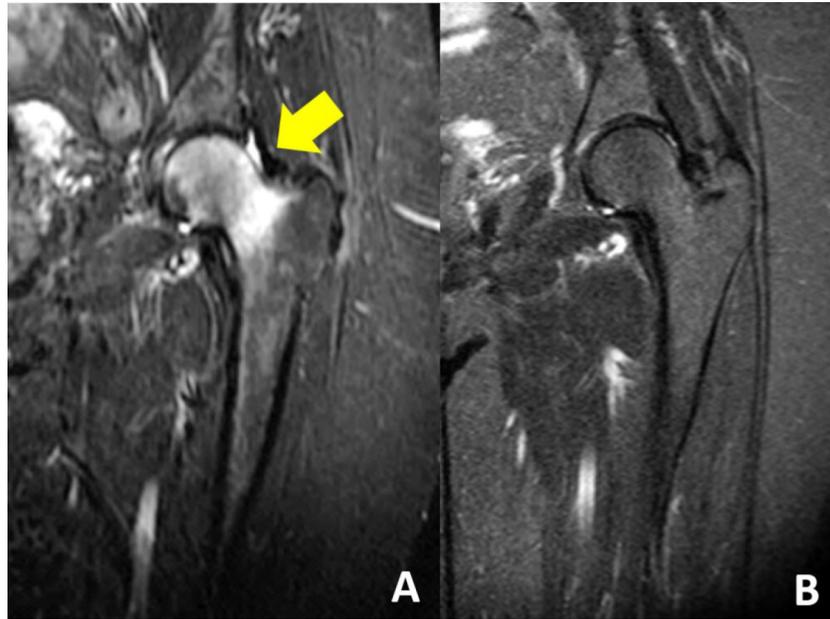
Magnetic resonance imaging (MRI) of the left hip of the patient before (A) and 3.5 months after (B) a zoledronic acid (ZA) infusion (Coronal T2-weighted with fat suppression). In November 2019, a MRI revealed extensive bone marrow edema (BME) in the left femoral head and neck (A, yellow arrow) and a single 5mg ZA infusion was administered. 3.5 months later, a second MRI of the left hip displayed resolution of BME (B).
